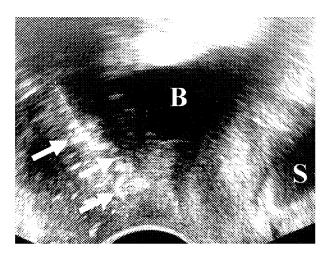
Introital ultrasound image (midsagittal view) showing the hyperechoic polypropylene mesh (arrows) with a wavy configuration 6 weeks after transobturator mesh interposition for cystocele repair. The mesh is located under the bladder neck and bladder base within the vesicovaginal space. B, bladder; S, symphysis.
